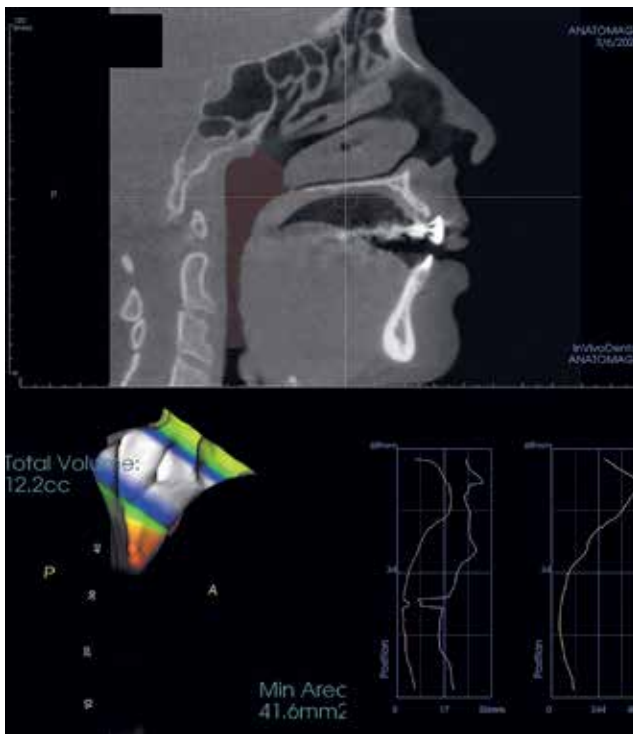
A CBCT midsagittal section with the airway highlighted (*red*); this is a special software application that provides volumetric measurements of the airway (*bottom*), a crucial tool in airway analysis.
